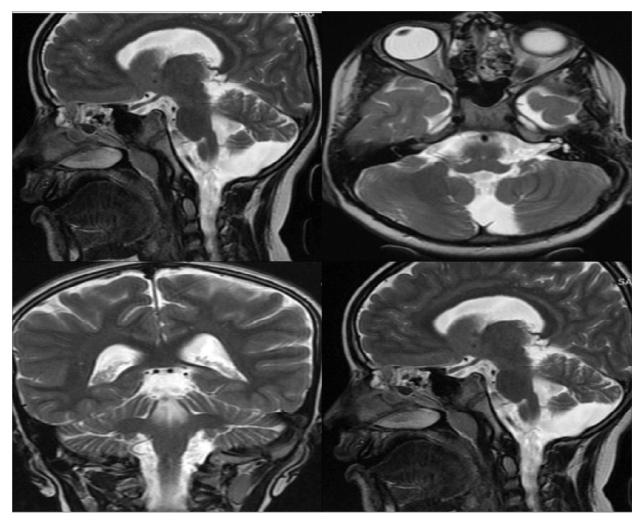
Magnetic resonance images of brain showing posterior fossa cyst of CSF density, communicating with enlarged fourth ventricle and hypoplastic vermis
